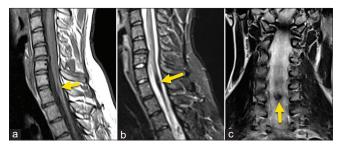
Sagittal T1-WI (a), sagittal (b), and coronal T2-WI (c) show a focal T2-hyperintense lesion (arrows) that is isointense on T1-WI and hyperintense on T2-WI, with surrounding hypointensity that suggests a cavernoma with hemosiderosis T1-WI = T1-weighted image, T2-WI = T2-weighted image
